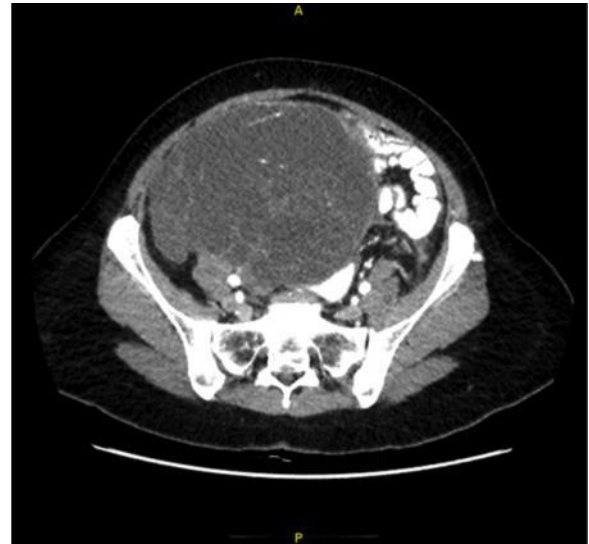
Follow-up CT-scan - appearance of a huge pelvic mass.
